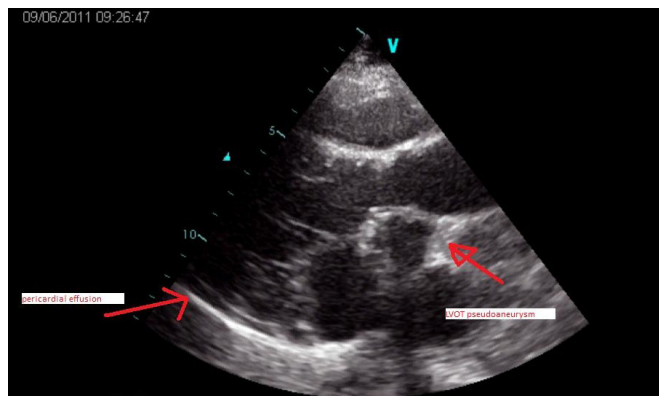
Transthoracic echocardiographic imaging of a perivalvular pseudoaneurysm and minimal pericardial effusion.
